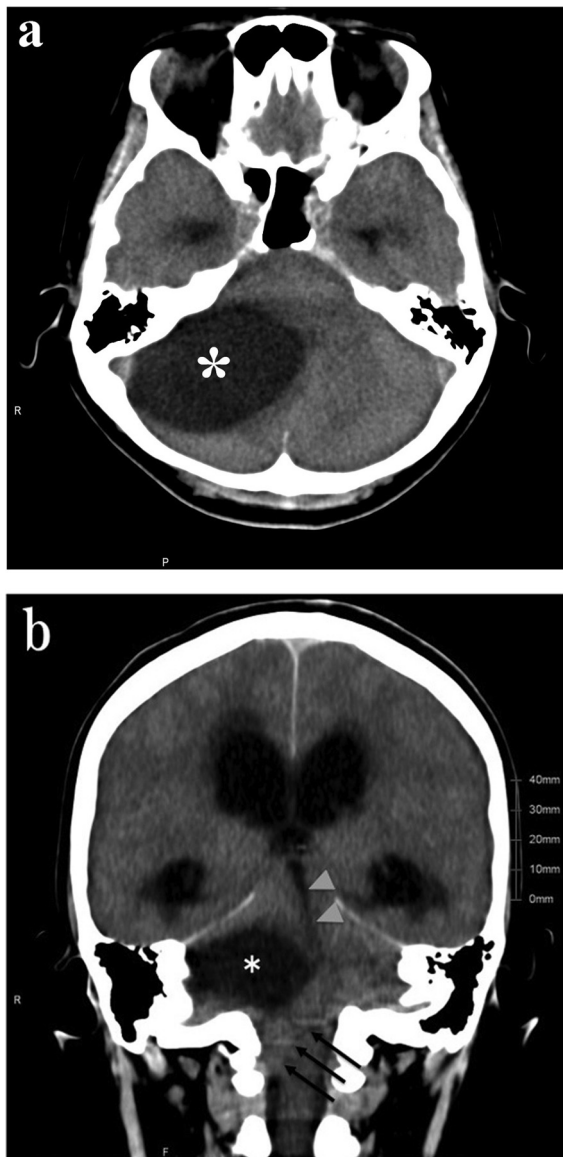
(a) Postmortem brain computed tomography (CT) at the level of the cerebellar hemisphere showing a large cyst (asterisk). (b) Postmortem coronal brain CT at the level of the brain stem showing enlargement of the lateral ventricles, a large right cerebellar cyst over the midline (asterisk), left shift and compression of the aqueduct (gray arrowheads), and transforaminal herniation (black arrows).
